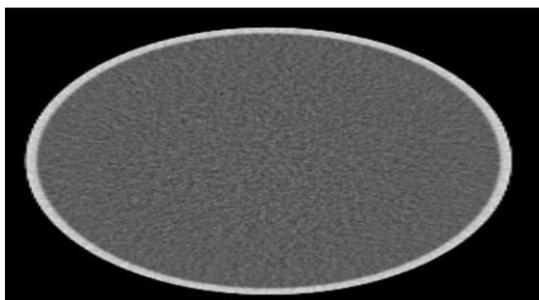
CT image for the homogenous water
